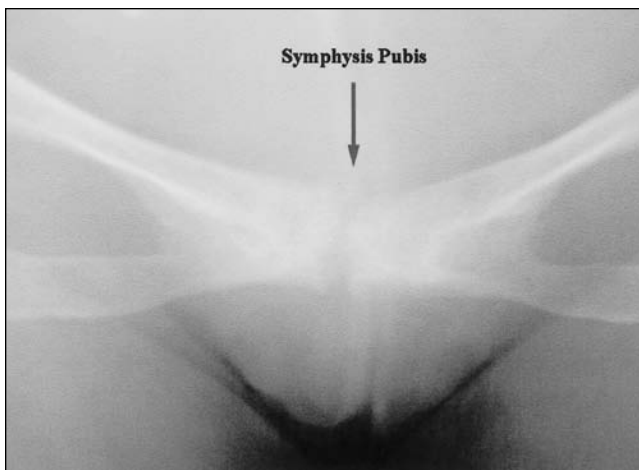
Plain radiograph of the pelvis with typical changes of osteitis pubis: an irregular joint line, subchondral sclerosis and cysts.
